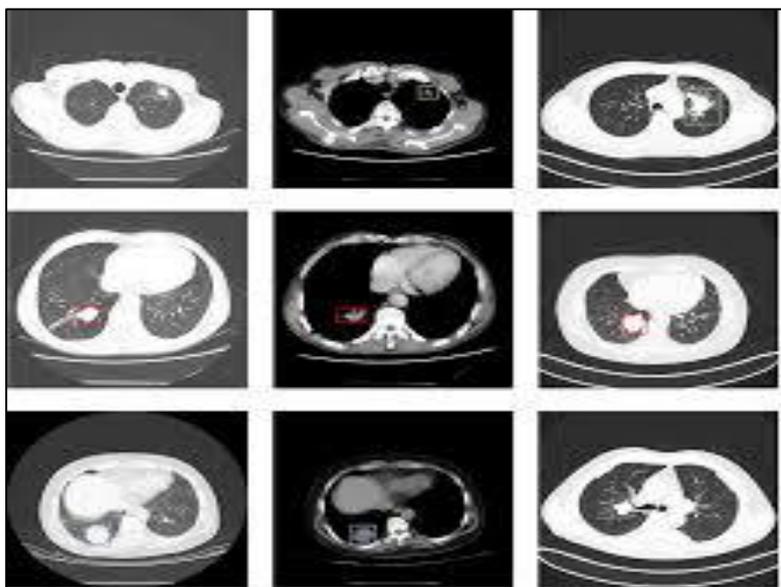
Instances of IQ-OTHNCCD dataset CT images [11-14]
